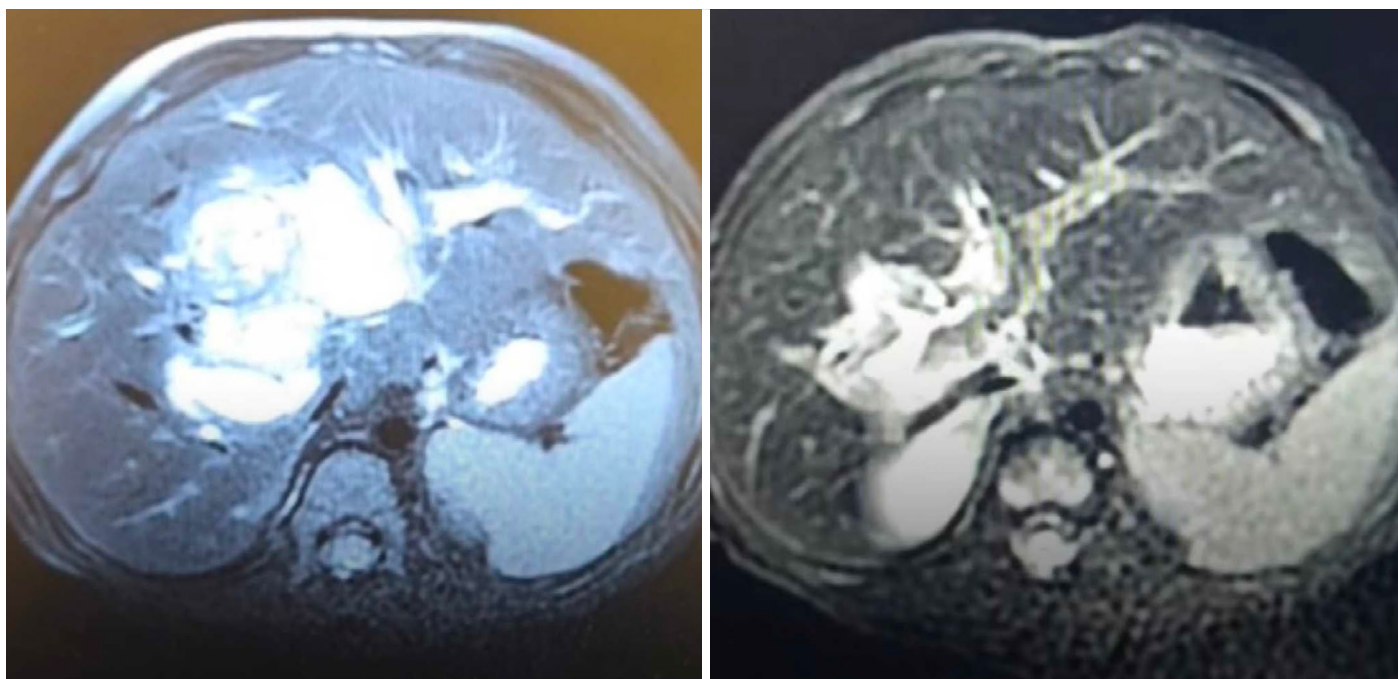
The MRI images of centrally located unresectable biliary RMS prior to and after the neoadjuvant chemotherapy.
